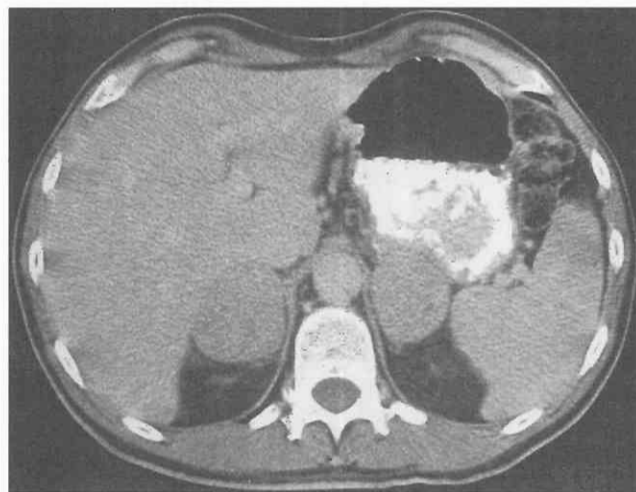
Non-Hodgkin's lymphoma. Contrast-enhanced CT scan of the abdomen demonstrates solid bilateral adrenal masses. Biopsy revealed the diagnosis.
